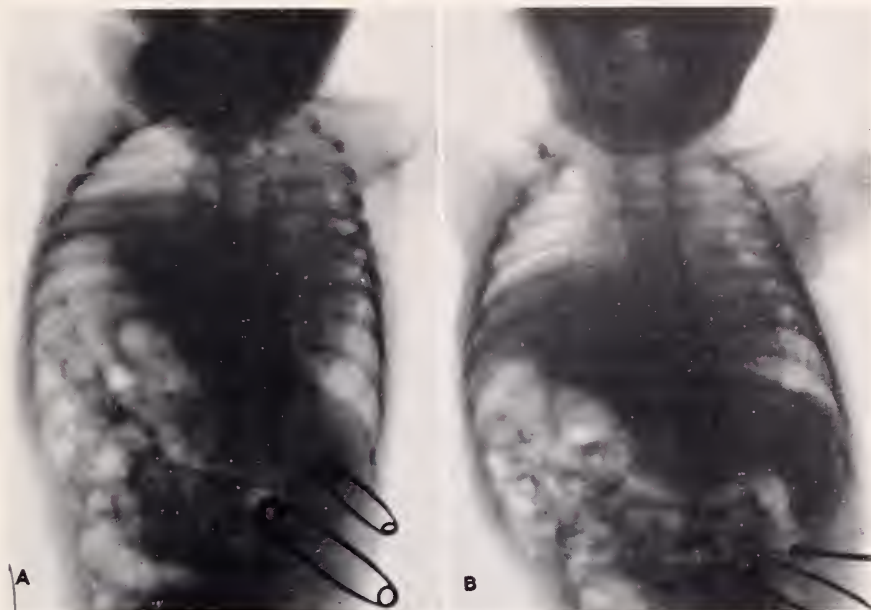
Roentgenograms of the chest. A, left, taken in inspiration, and B, right, taken in expiration, showing marked elevation and paradoxical motion of the right leaf of the diaphragm, with shift of the mediastinum to the left on inspiration.
